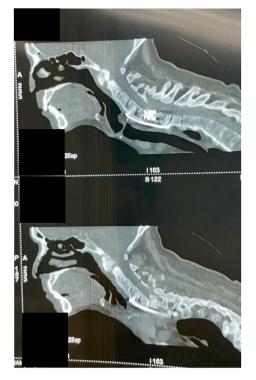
Control CT-SCAN shows the moving of the cage.
